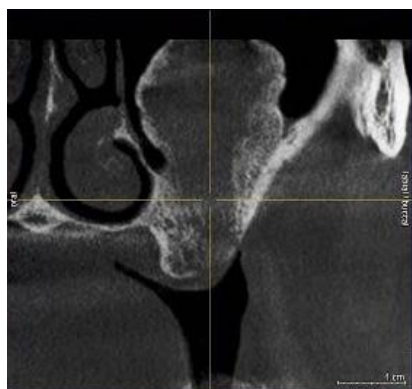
Six months post-operative CBCT with bone fill of the cystic site
